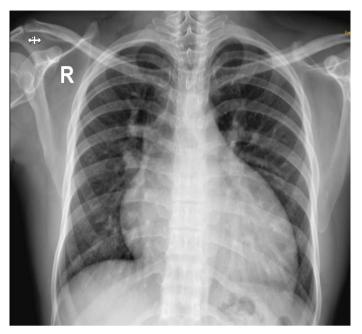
Preoperative chest X-ray demonstrates prominent pulmonary vasculature (active congestion) without pleural effusions. Enlarged cardiac silhouette.
